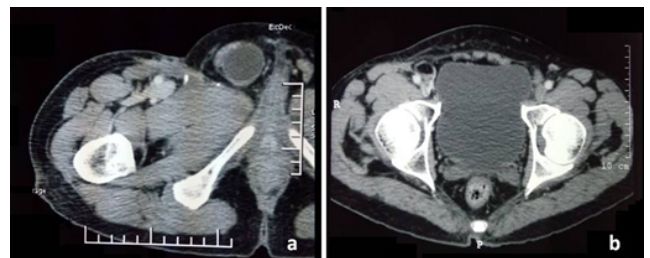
a): Postoperative CT angiography of right lower limb showed well-defined hypodense, multiloculated cystic area 4.2 x 3.2 x 5 cm with peripheral enhancement in anteromedial aspect of thigh; b): Post chemoradiotherapy CECT scan showed no residual tumor
